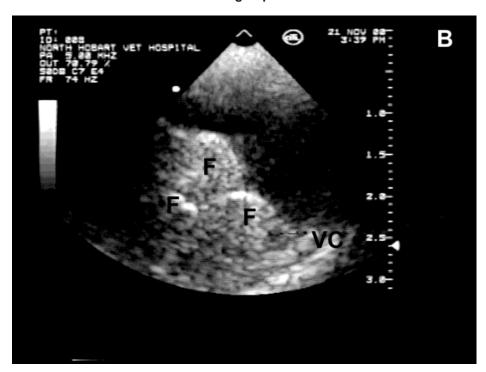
Imaging appearance of reproductive structures in female *Tiliqua nigrolutea* during the period encompassing ovulation (November). A: Radiographic appearance of the body postovulation. Follicles (F) are arranged linearly in the oviduct. The lungs (L) appear as nonsymmetrical radio-lucent areas. Scale bar represents 20 mm. B: Ultrasound appearance of the ovary prior to ovulation. Follicles (F) are grouped together adjacent to the vertebral column (VC). Vertical scale bar measures distance in cm from transducer. C: Ultrasound appearance of an ovulated follicle (F) in the oviduct. Only a single follicle is visible in the image plane, located adjacent to the vertebral column (VC). Movement of the image plane along the body revealed more follicles arranged linearly in the oviduct. Vertical scale bar measures distance in cm from transducer.
